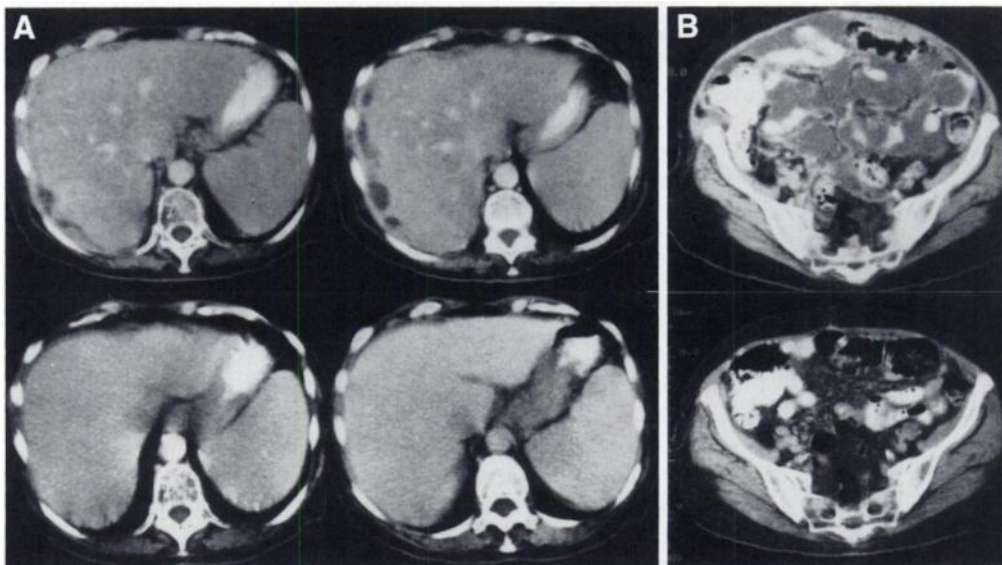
CT scan of the abdomen 2 wk before the first radioimmunotherapy with radiolabeled MN-14 (top) and 3.5 mo post-therapy (bottom) shows complete regression of capsular liver metastases (A). CT scan of the pelvis 2 wk before the first radioimmunotherapy with radiolabeled MN-14 (top) and 3.5 mo post-therapy (bottom) shows complete regression of peritoneal implants previously apparent as "pancaking" and resolution of ascites (B).
